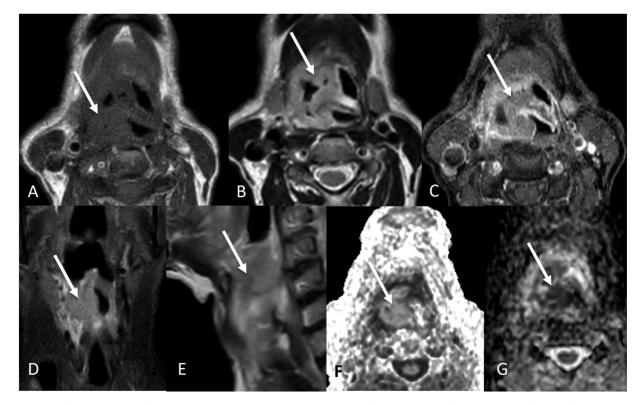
Transglottic cancer. Axial T1W (A), T2W (B), post contrast T1W (C), coronal STIR (D), sagittal T2W (E) images showing the T1 isointense, T2 intermediate intensity, STIR hyperintense heterogeneously enhancing mass (arrows) involving the supraglottis and glottis. The mass shows restricted diffusion as seen on axial DWI and ADC images (F and G).
